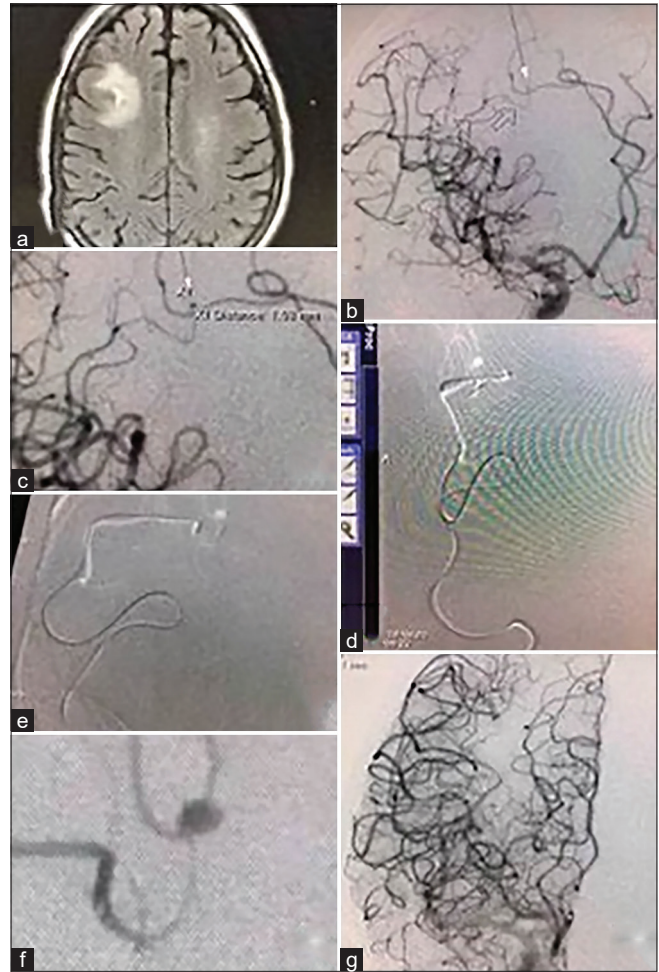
(a) MRI Flair sequence shows right frontal lesion with surrounding edema and subarachnoid hemorrhage consistent with cerebral abscess and ruptured mycotic aneurysm. (b and c) Digital subtraction angiography anterior-posterior and oblique views shows mycotic aneurysm measuring 1 mm. (d and e) show roadmap angiography with microcatheter approach to the aneurysm. (f) Microcatheter injection just proximal to the mycotic aneurysm. (g) Internal carotid artery digital subtraction angiography after onyx embolization of the mycotic aneurysm with no residual filling and no unintended thromboembolic phenomena.
